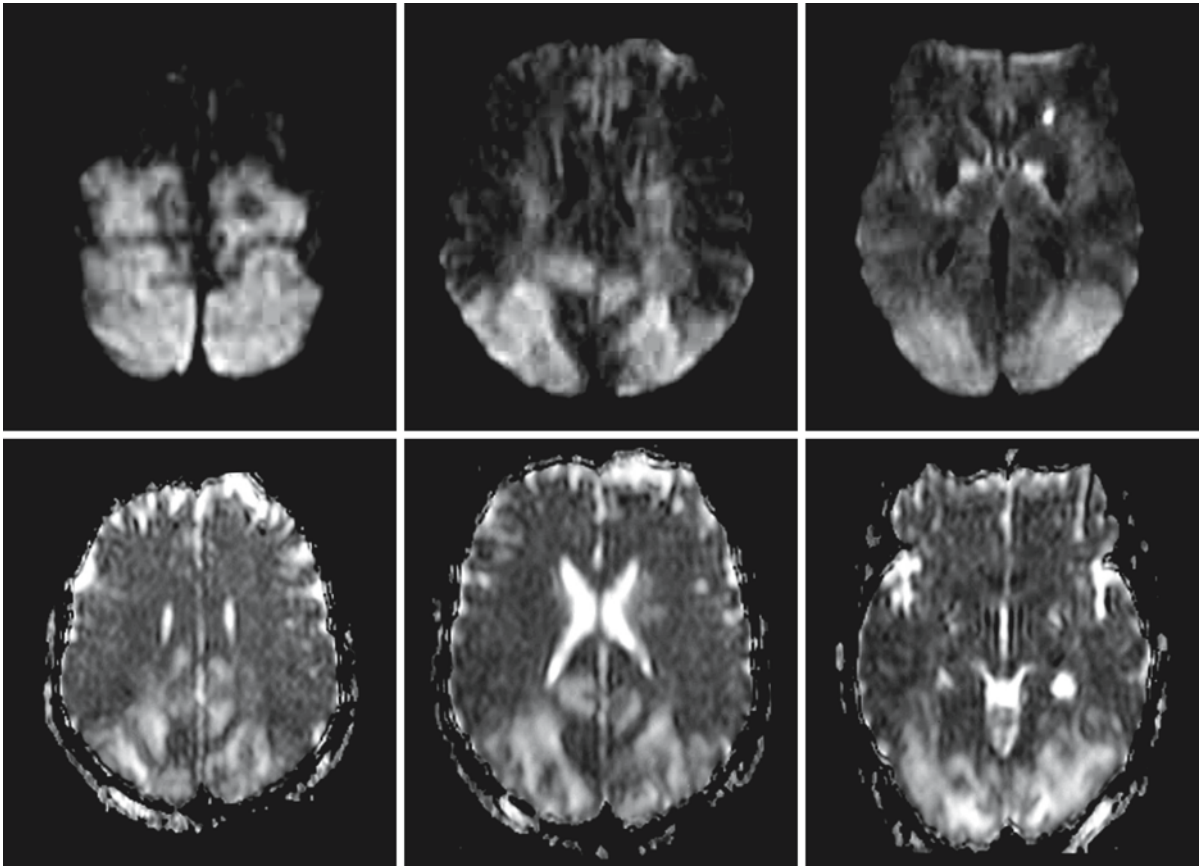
(continued). A 39-year-old nurse committed suicide using fentanyl dermal patches. The T_2 -weighted images (first and second rows) show predominant involvement of the parieto-occipital areas, but also involvement of the basal ganglia (especially the globus pallidus) and the posterior limb of the internal capsule. The FLAIR images (third and fourth rows) more clearly show that there is also cerebellar involvement.
